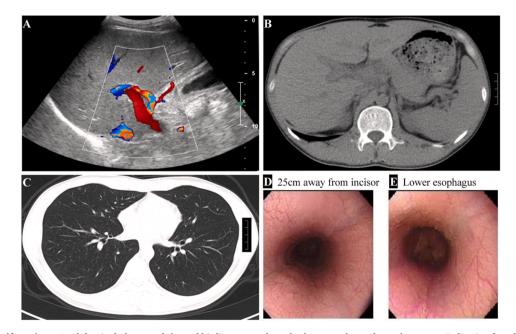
Imaging manifestations. A. Abdominal ultrasound showed his liver parenchymal echo was enhanced, rough, uneven, indicating fatty liver and parenchymal injury. B. Computed tomography of abdomen showed splenomegaly, portal hypertension with open collateral circulation, possible cirrhosis. C. Computed tomography of chest showed a small nodule in the middle lobe of right lung. D and E. Gastroscopy displayed two veins visible 25 cm away from the incisor.
